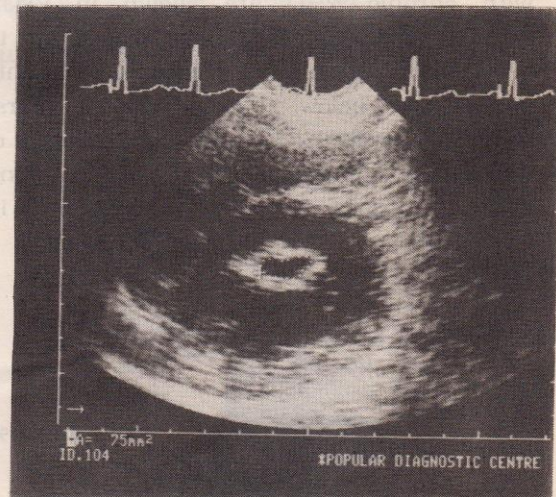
Parasternal short-axis view through the tips of the mitral leaflets demonstrating the valve orifice. Planimetry of the mitral valve orifice area was performed at the onset of diastole.
